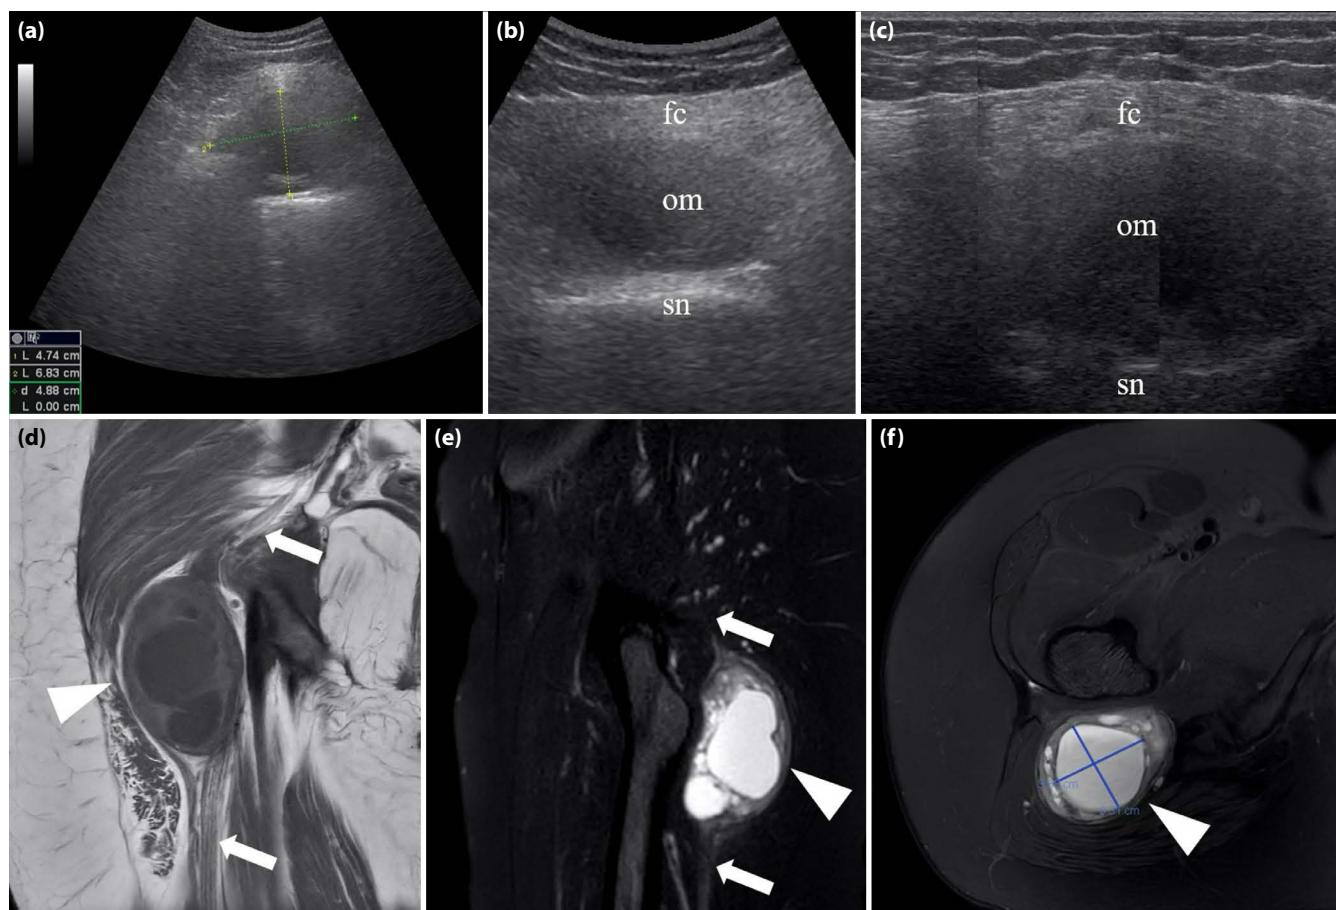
Axial ultrasound imaging with a convex probe (a, b) and a linear probe (c) demonstrates a hypoechoic oval mass adjacent to the sciatic nerve with its hyperechoic fibrillar capsule. Coronal T1-weighted (d), sagittal T2-weighted (e), axial T2-weighted (f) MRI sequences of a well-defined encapsulated peripheral nerve sheath tumor between gluteal and adductor muscles in the posterior upper third of the thigh.
